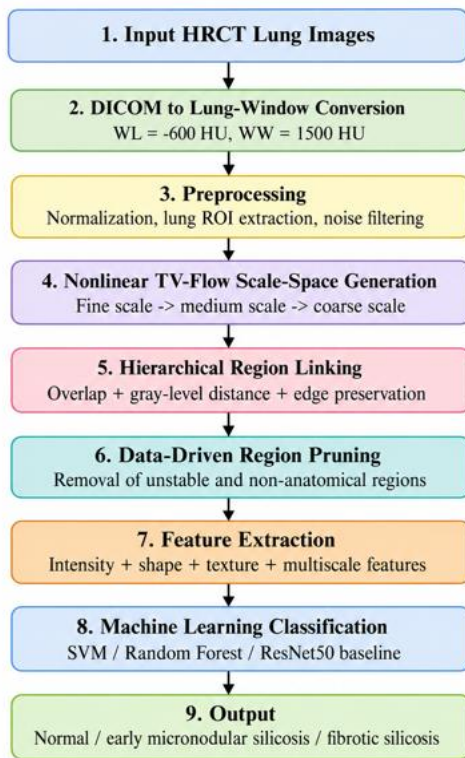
Proposed methodology for silicosis detection using HRCT data
